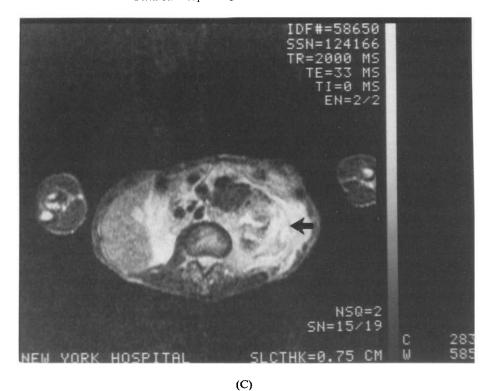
continued. (C) SE 2000/85 MR image demonstrates heterogeneous increased signal intensity within the mass (arrow).
